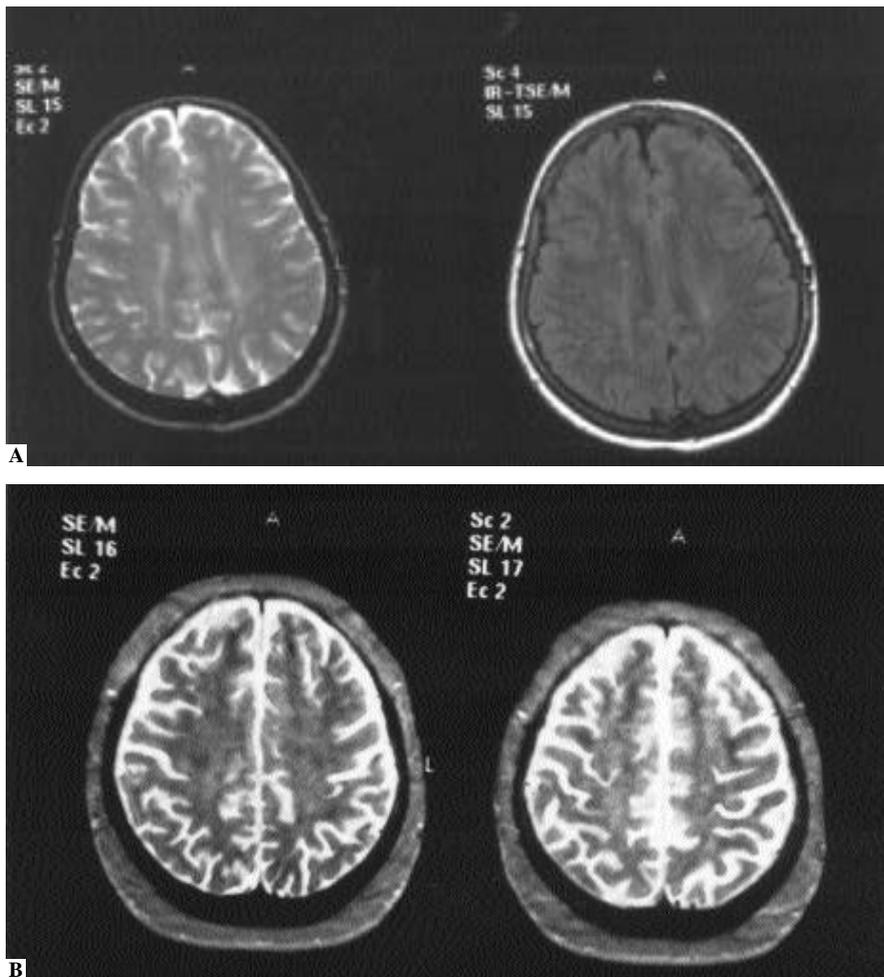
(A) VP, a 20-year-old girl with a history of chorea, psychosis and TIA. Supraventricular microinfarcts shown in a transverse spin echo T2w sequence (TR 230 ms, TE 90 ms, FOV 250 mm, 5 mm thickness) and a transverse FLAIR sequence (TR 9000 ms, TE 150 ms, TI 2660 ms, FOV 250 mm, 5 mm thickness). (B) RJ, a 14-year-old girl with headache and numbness. Transverse spin echo T2w sequence (TR 230 ms, TE 90 ms, FOV 250 mm, 5 mm thickness) shows diffuse cortical atrophy.
